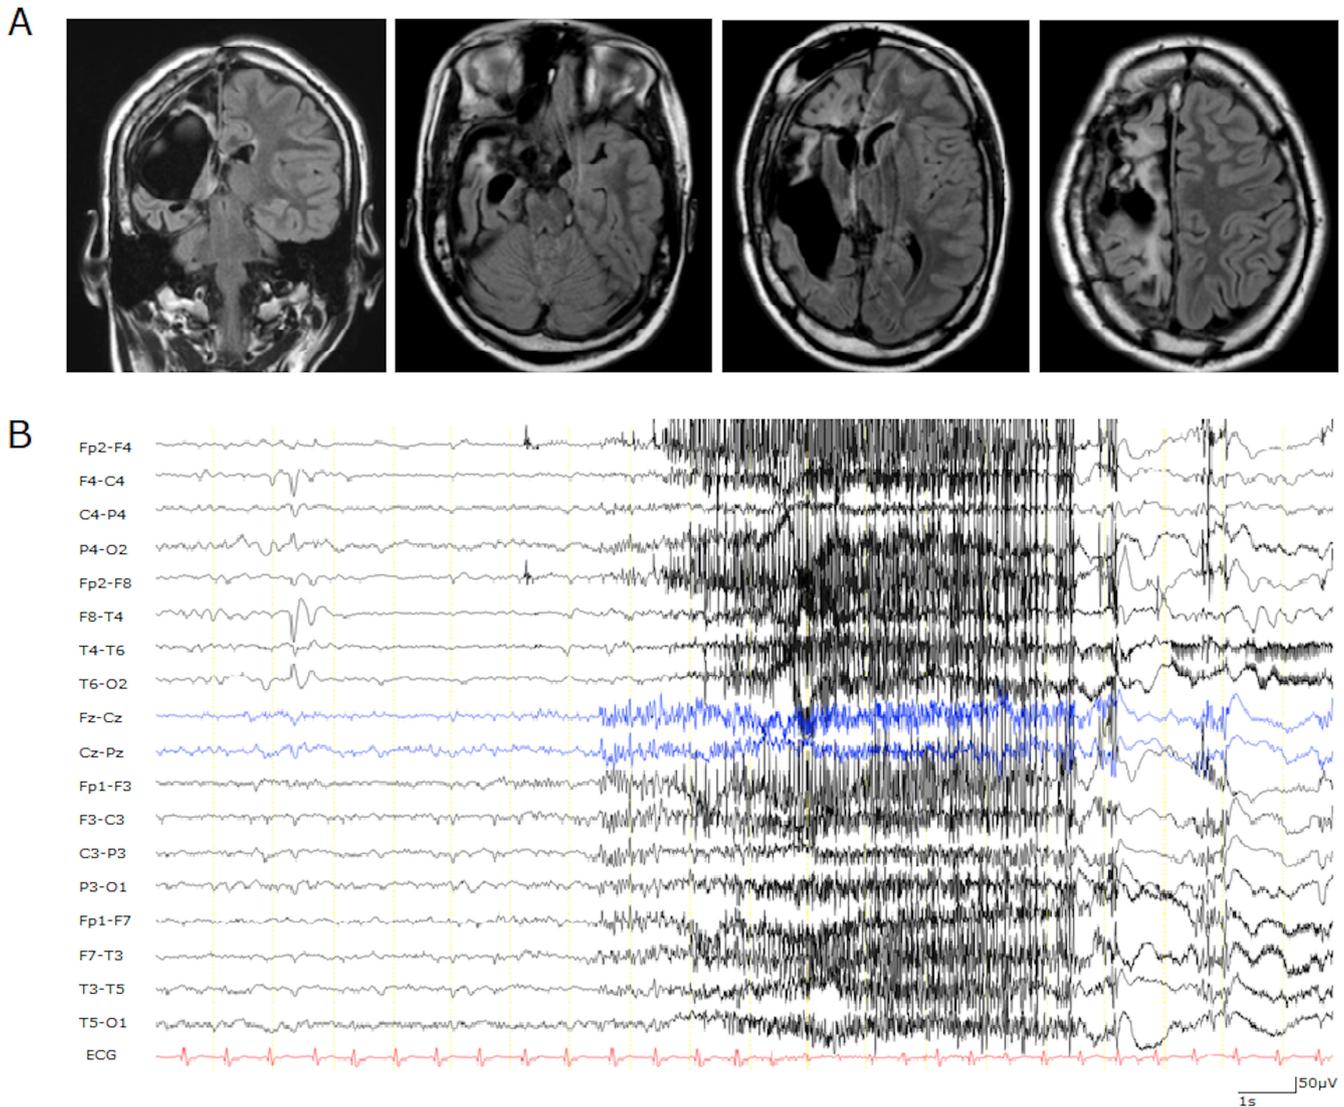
Neuroradiological and electroencephalographic features. (A) Brain MRI was performed at the age of 17 years after peri-insular hemispherotomy. Severe atrophy of the right hemisphere, with enlarged subarachnoid spaces in the right frontotemporal regions in coronal and axial T2-weighted fluid-attenuated inversion recovery (FLAIR) images. (B) Ictal EEG during a brief left tonic-dystonic seizure initially shows a slow wave over the right frontotemporal regions followed by a diffuse rhythmic spiky activity maximal on the left hemisphere.
